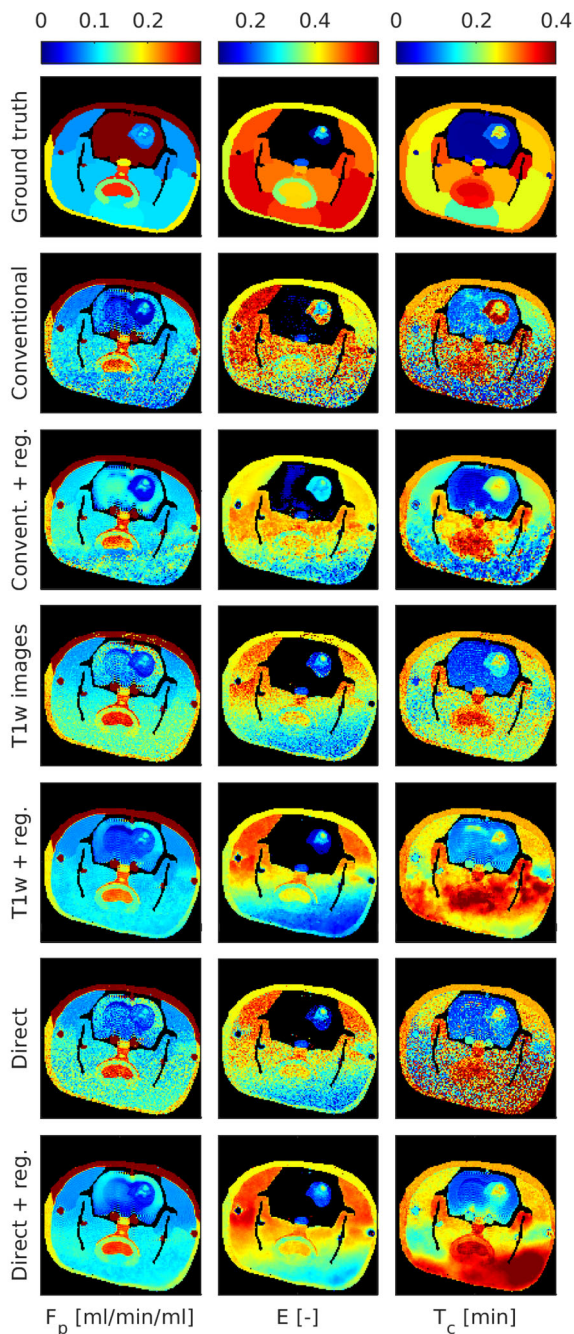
Comparison of the DCE-MRI fitting approaches (defined in Table 1) with and without spatial regularization. Only three out of five perfusion-parameter maps are shown.
